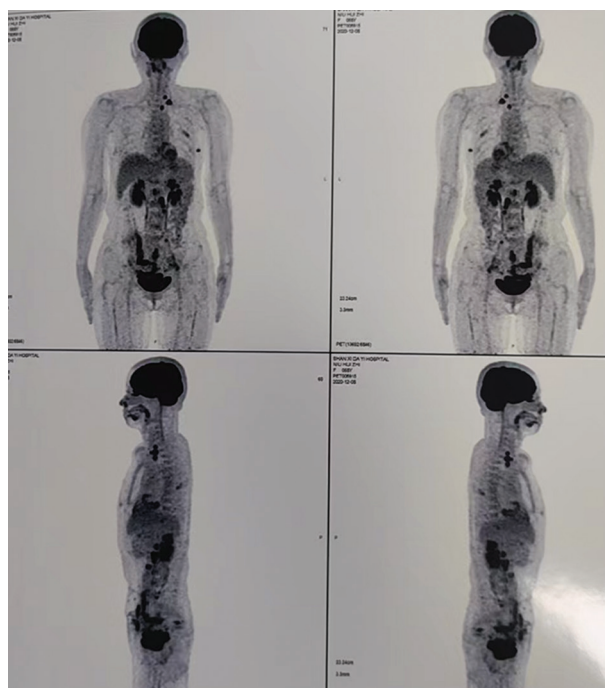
Image of positron emission tomography-computed tomography scan taken in December 2020
